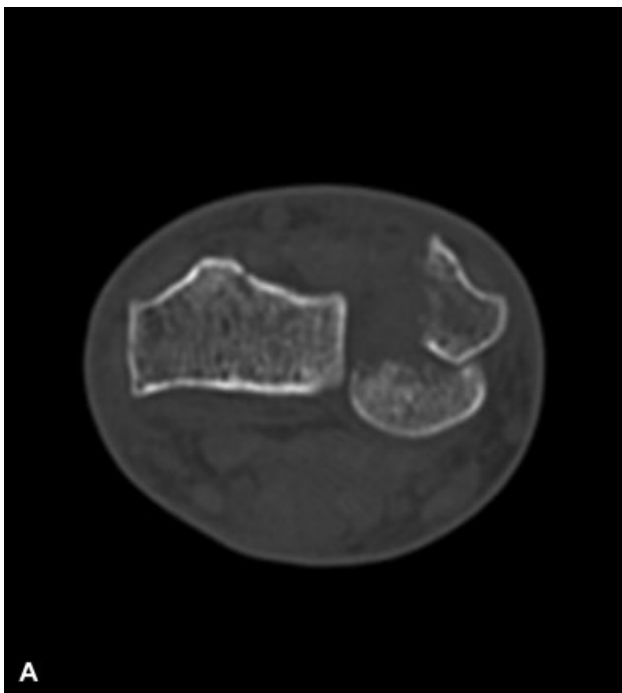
(A) Axial computed tomography (CT) view of the distal radioulnar joint (DRUJ) in 90° of forearm pronation. The displaced fragment of the ulnar head involves the DRUJ. (B) Axial CT view of the DRUJ in 90° of forearm supination. The displaced ulnar head fragment is reduced.
